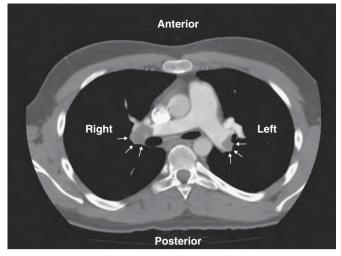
Computed tomographic angiography in a patient with pulmonary embolism. Large thrombi are seen in both the right and left pulmonary arteries.
